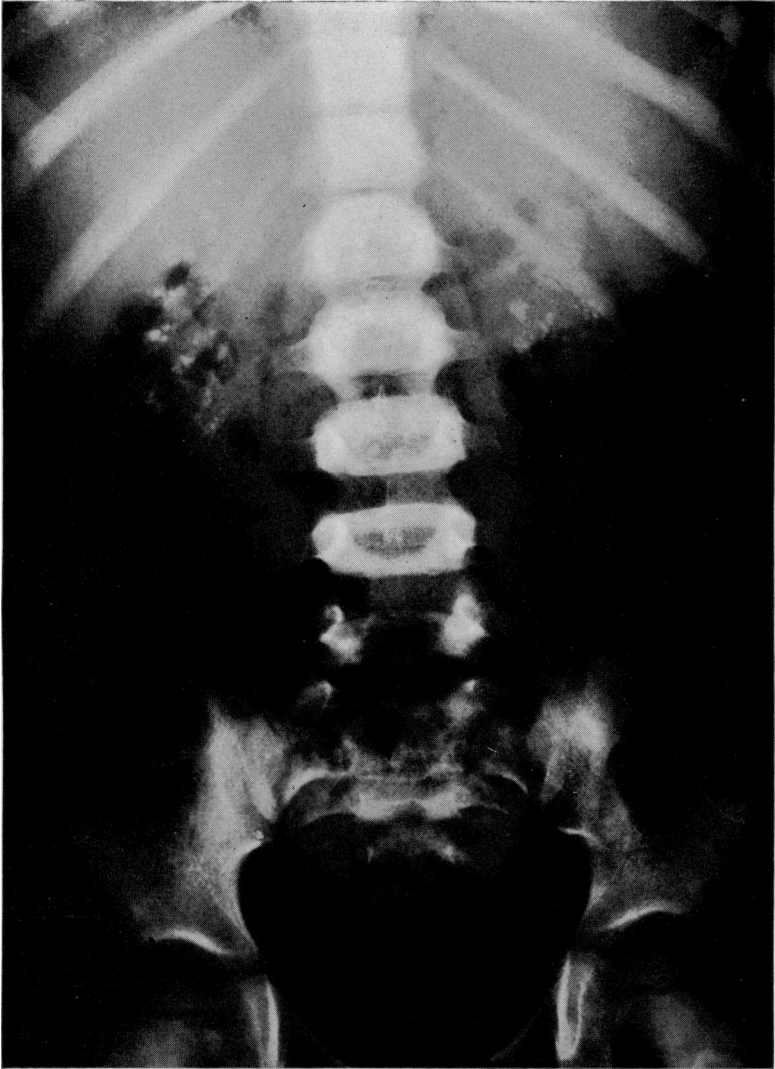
Radiograph showing marked diffuse bilateral calcification of the renal parenchyma.
